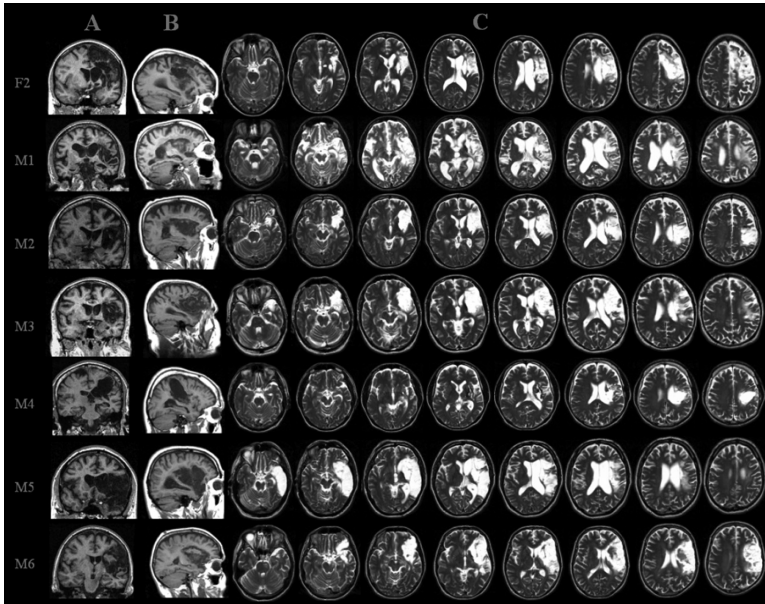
Structural MRI scans: Column A represents a T1-weighted coronal section through the mid-temporal region; Column B represents a T1-weighted sagittal section on the side with the lesion (right in these patients); and Column C displays a series of axial T2-weighted scans in 7.5 mm steps. The right hemisphere is shown on the right. (Thanks to Jerome Maller for preparing the figure.)
